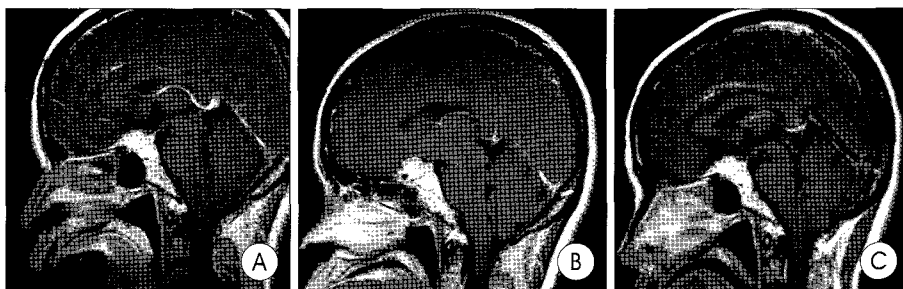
Patient 5. Sagittal magnetic resonance image demonstrating a parasellar meningioma at the time of diagnosis (A), after 60 months (B), and after 90 months (C). There are no grossly significant changes in the size of the tumor.
